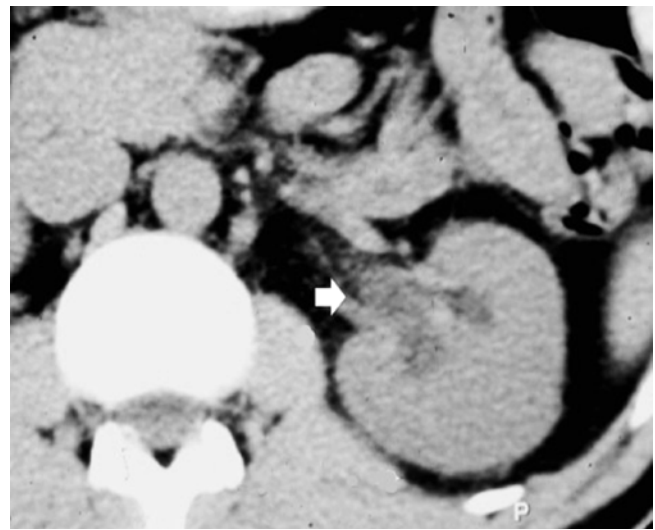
Indirect signs of renal calculi. Unenhanced CT. Transverse plane. Renal sinus fat blurring (*arrow*) with increased density of the sinus fat (Courtesy of Prof. E. Quaia)
